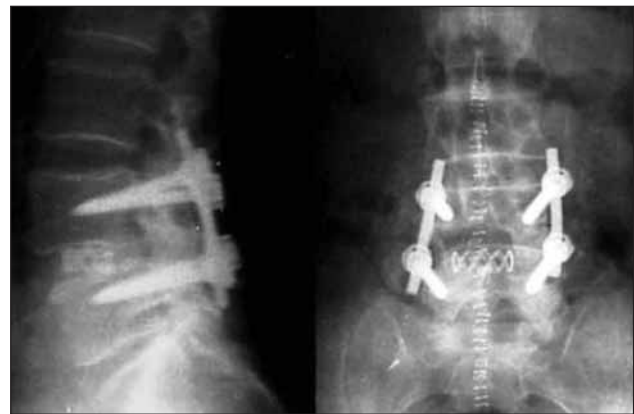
Anteroposterior and lateral X-rays showing bilateral L4 partial hemilaminectomies with medial facetectomies, bilateral L4 and L5 foraminotomies and L4-L5 discectomy followed by posterior interbody fusion with mesh and bone graft and L4-L5 posterior transpedicular fixation
